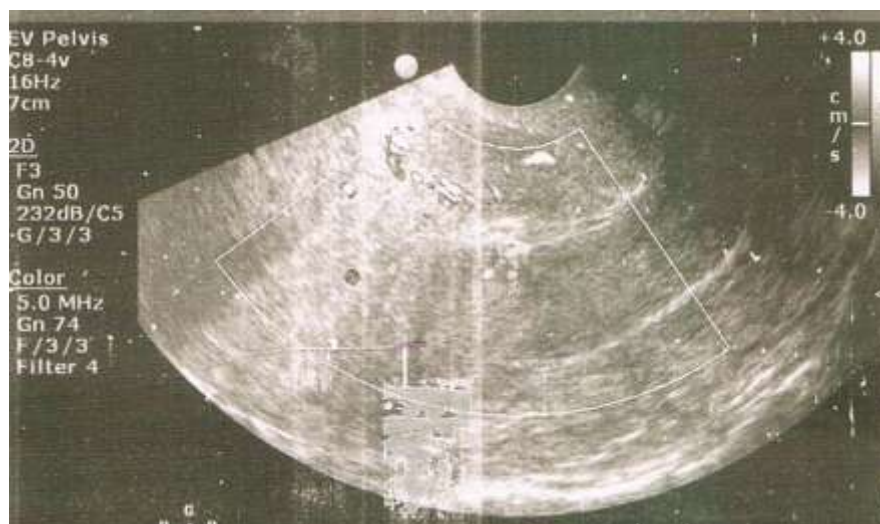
The transvaginal sonography showing retained products with negative CDI
